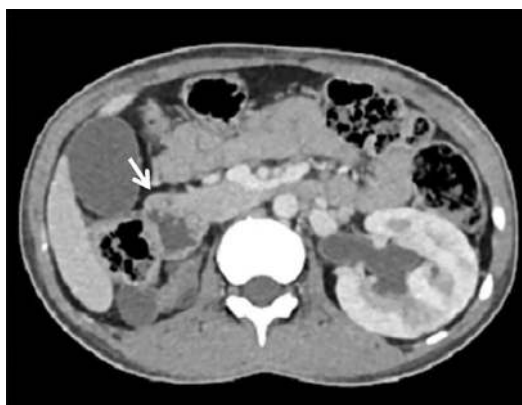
Axial contrast CT showing rim of pancreatic tissue (arrow) anterolateral to the duodenum in a case of incomplete annular pancreas
